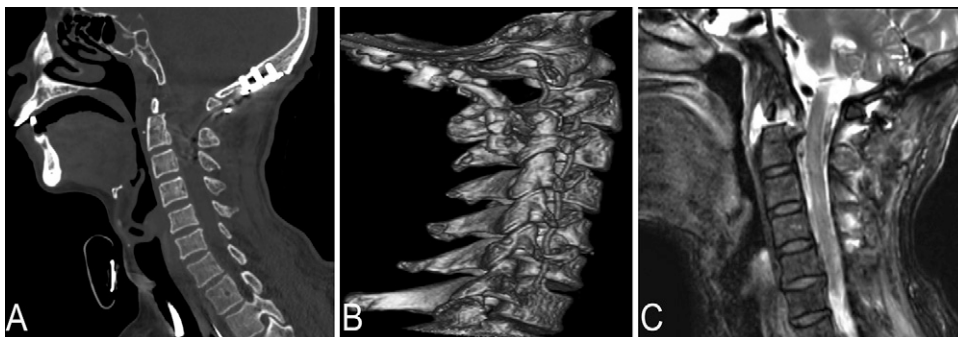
Acceptable alignment of the atlantoaxial junction was shown on the postoperative sagittal CT reconstruction (A). Compared with preoperatively, the course of the right vertebral artery had returned to normal according to three-dimensional CT angiography (B). MRI after the operation confirmed that spinal cord compression was relieved (C).
